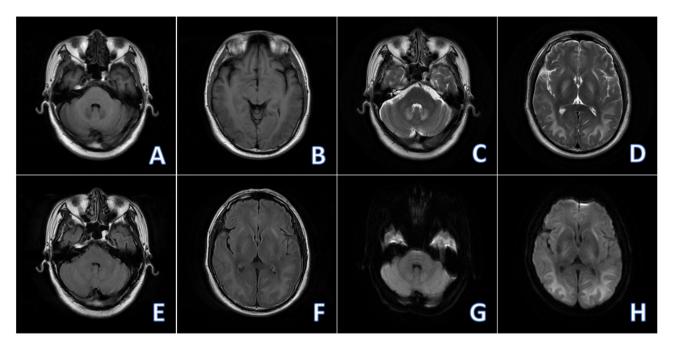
Non-contrast brain MRI (at 15 days post-admission). (A-H) There were reductions in the extent of the abnormal signal in the brain and in the DWI intensity of the lesion, compared with (at 11 days post-admission). MRI, magnetic resonance imaging; DWI, diffusion-weighted imaging.
